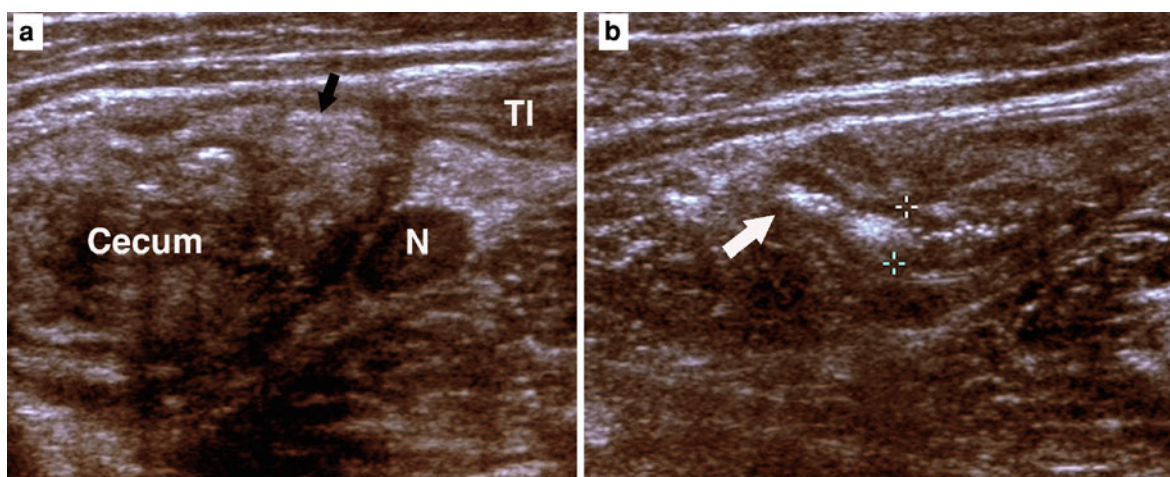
a, b Camphylobacter ileocolitis mimicking appendicitis. a is transverse grayscale sonogram of cecum demonstrating marked mural thickening with increased echogenicity and thickening within submucosal layer (*black arrow*), indicating submucosal edema, note enlarged pericecal lymph node (“N”;
